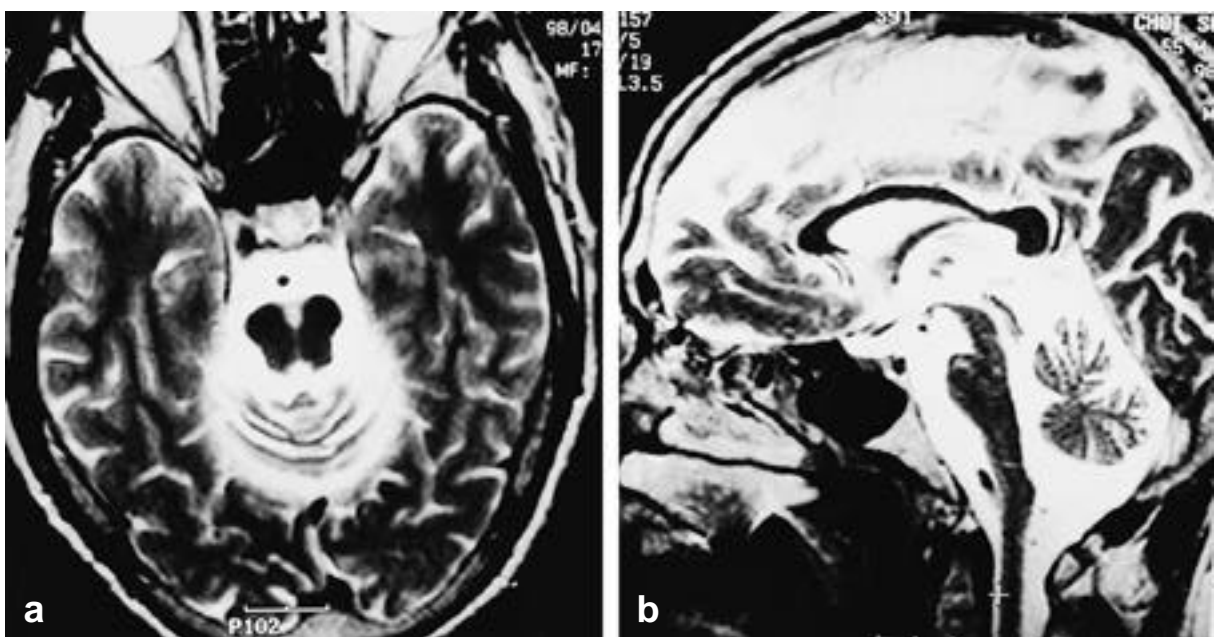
Magnetic resonance images of the patient's father show moderate cerebellar and brain stem atrophy(a. axial view, b. sagittal view).
